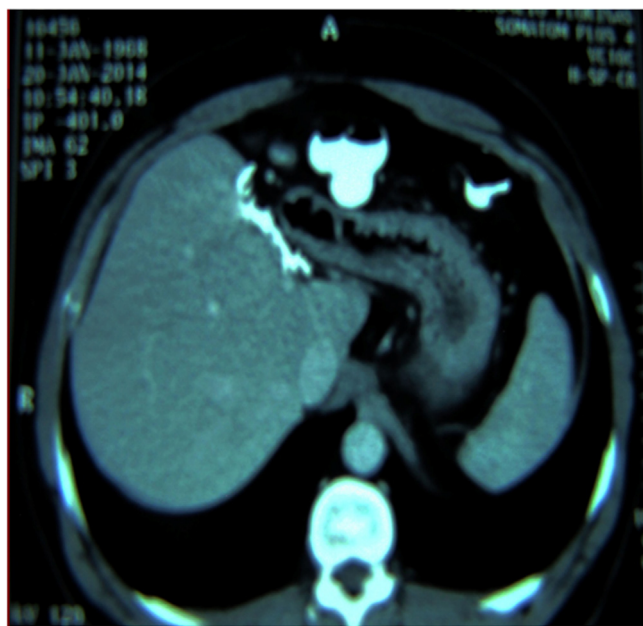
CT showing the liver remnant with compensatory hyperplasia seven months after hepatectomy and no recurrence or other abnormal finding in the first case.
